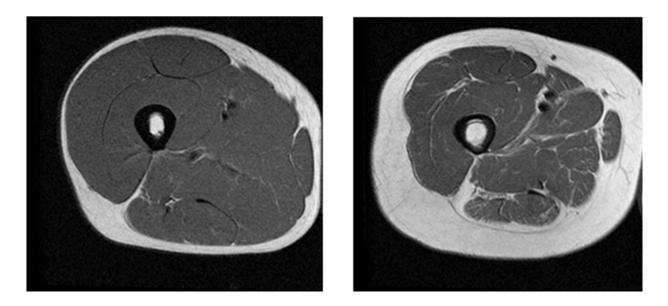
Changing of the cross-sectional area (magnetic resonance imaging) of a muscle (thigh) during aging: 25 years old on the left; 65 years old on the right.
